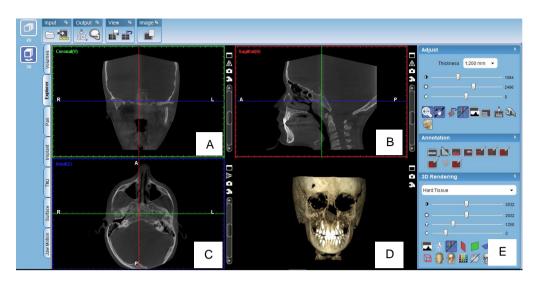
Preview Window CBCT of a patient (Planmeca Romexis®). A- Coronal plane view; B- Sagital plane view; C- Axial plane view; D- 3D reconstruction; E- Image tools.
